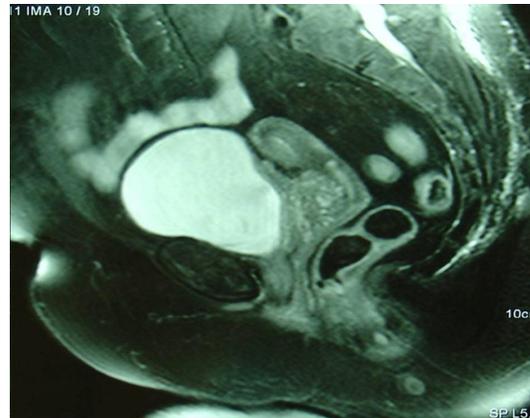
Magnetic resonance imaging revealing focal thickness of the bladder wall due to the development of fibrous tissue extending from the lower part of the external surface of the bladder to the anterior surface of the uterus.
